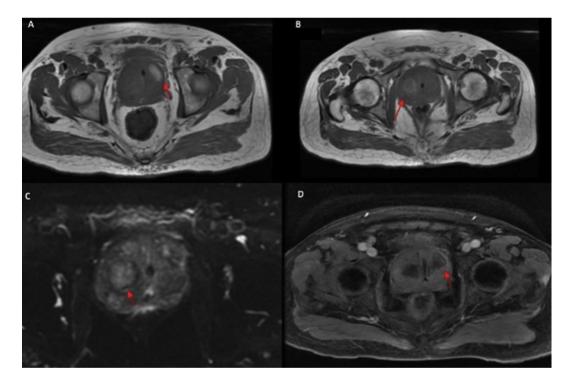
(A,B) Prostate MRI T1 weighted phase showing the two hyperintense areas. (C) Prostate MRI showing no diffusion restriction. (D) Prostate MRI showing no peripheral enhancement at the T2 weighted phase after contrast infusion.
